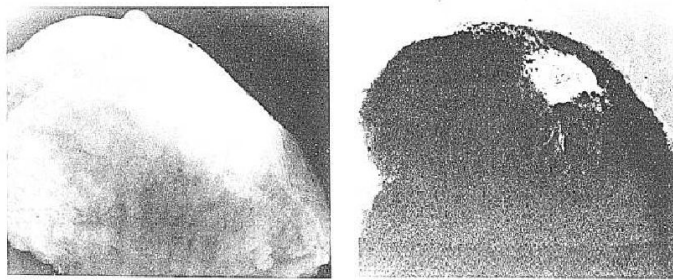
Left: Conventional X-ray radiograph. Right: Corresponding oxygen-ion radiograph (Sommer et al., 1978)
